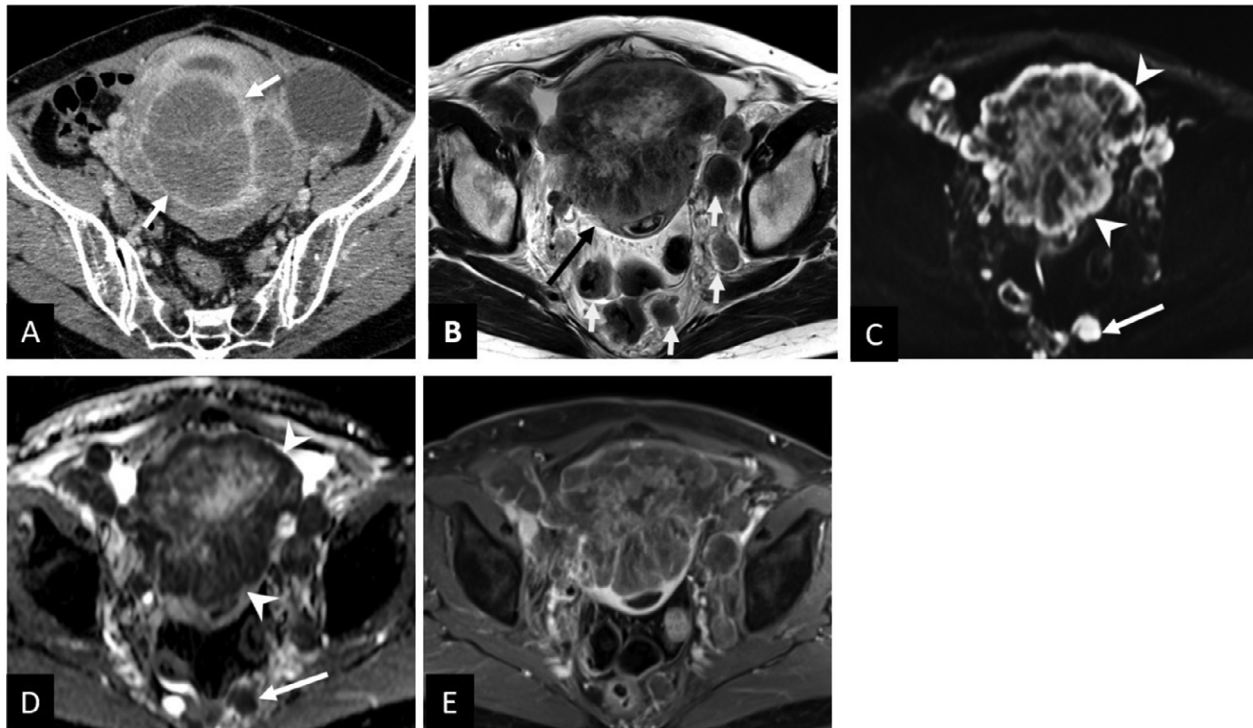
(A) Axial contrast-enhanced CT scan shows a bulky mass (arrows) in the uterus with heterogeneous enhancement, suggesting the presence of necrosis. (B) Axial T2-weighted MR image demonstrates the mass (long black arrow) of heterogeneous intensity in the endometrial cavity and multiple lymphadenopathies (short white arrows). (C) Axial diffusion-weighted image shows hyperintensity with border-predominant (white arrowheads) of the mass and lymphadenopathy (long white arrows). (D) ADC map shows low signal intensity in the same site of DWI hyperintensity. (E) Axial contrast-enhanced T1-weighted MR image shows the mass of heterogeneous intensity.
